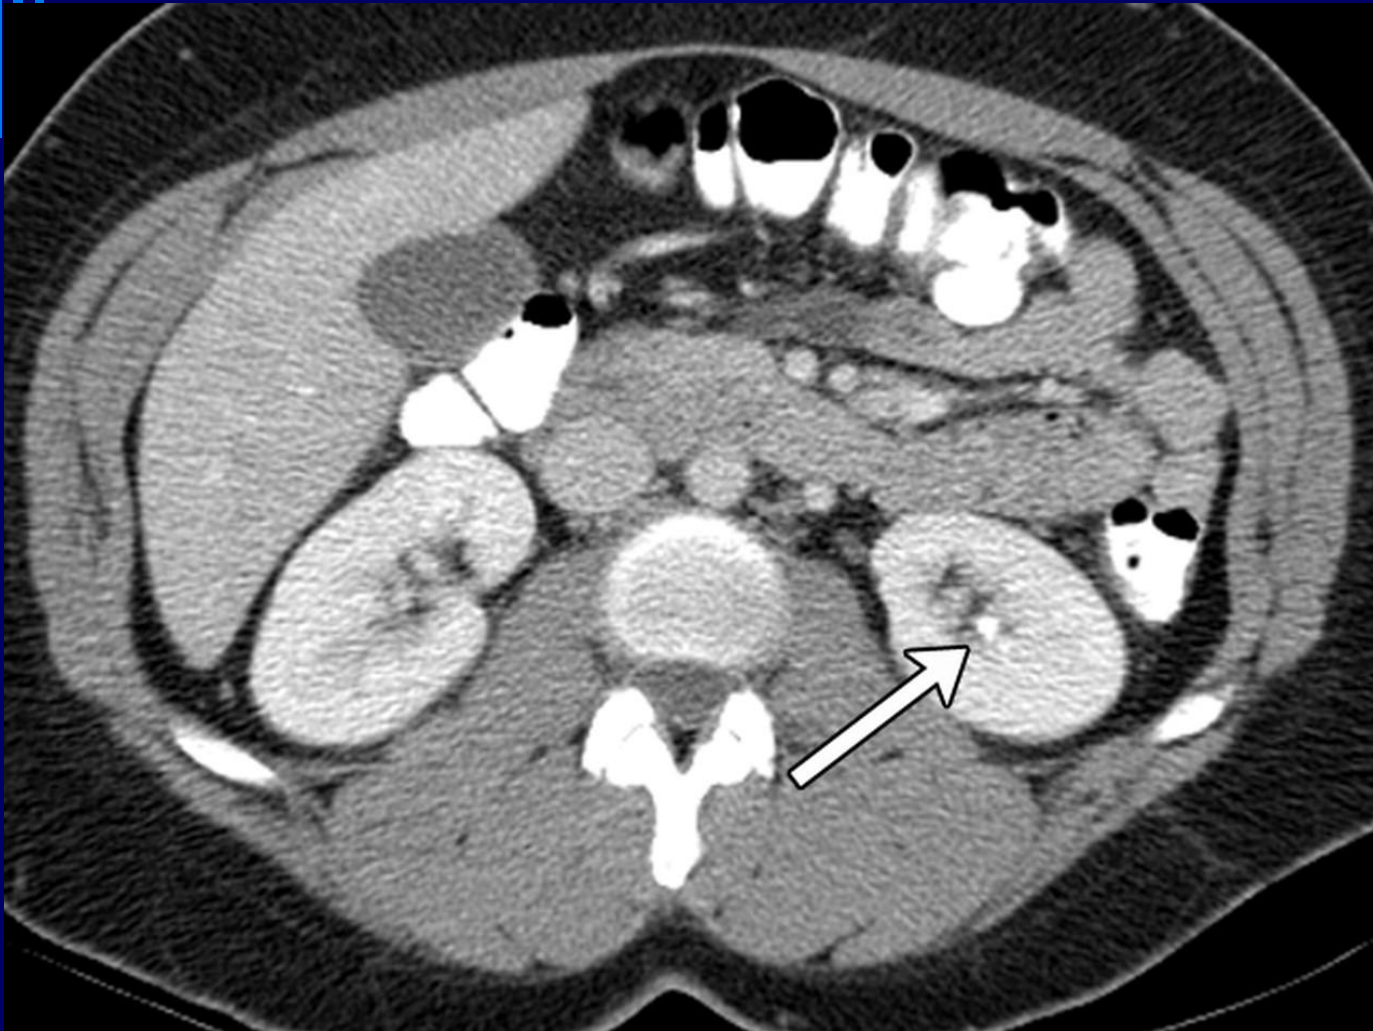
CT scans in a 36-year-old woman with abdominal pain
